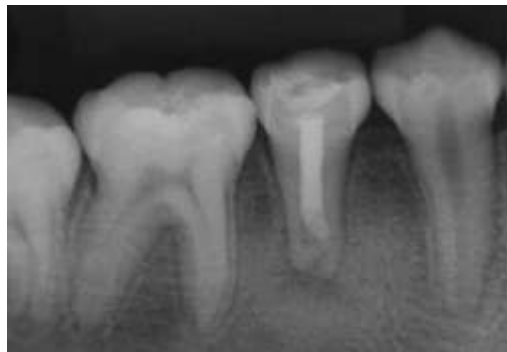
X-ray of preservation after 7 months of treatment
